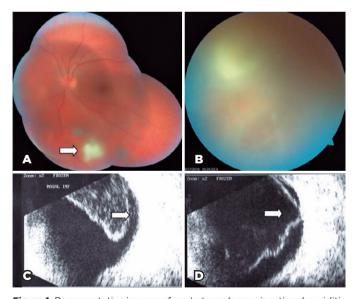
Representative images of acute toxoplasmosis retinochoroiditis (A) White focal retinitis (arrow) and a moderate vitreous inflammation accompanied by proximal pigmented retinochoroidal scars. (B) Focal retinitis with overlying vitreous inflammation. (C) and (D) B-scan ultrasound images. 1C. Vitritis appears as punctate echoes in the vitreous cavity, total posterior vitreous detachment, and hyaloid thickening. Lesions are indicated by arrows, and ultrasonography could not distinguish changes in the contours. (D) Appearance of a whitish lesion in the eye shown in figure 1B. Posterior vitreous detachment with adherence of the hyaloid to the exudative lesion is demonstrated.
